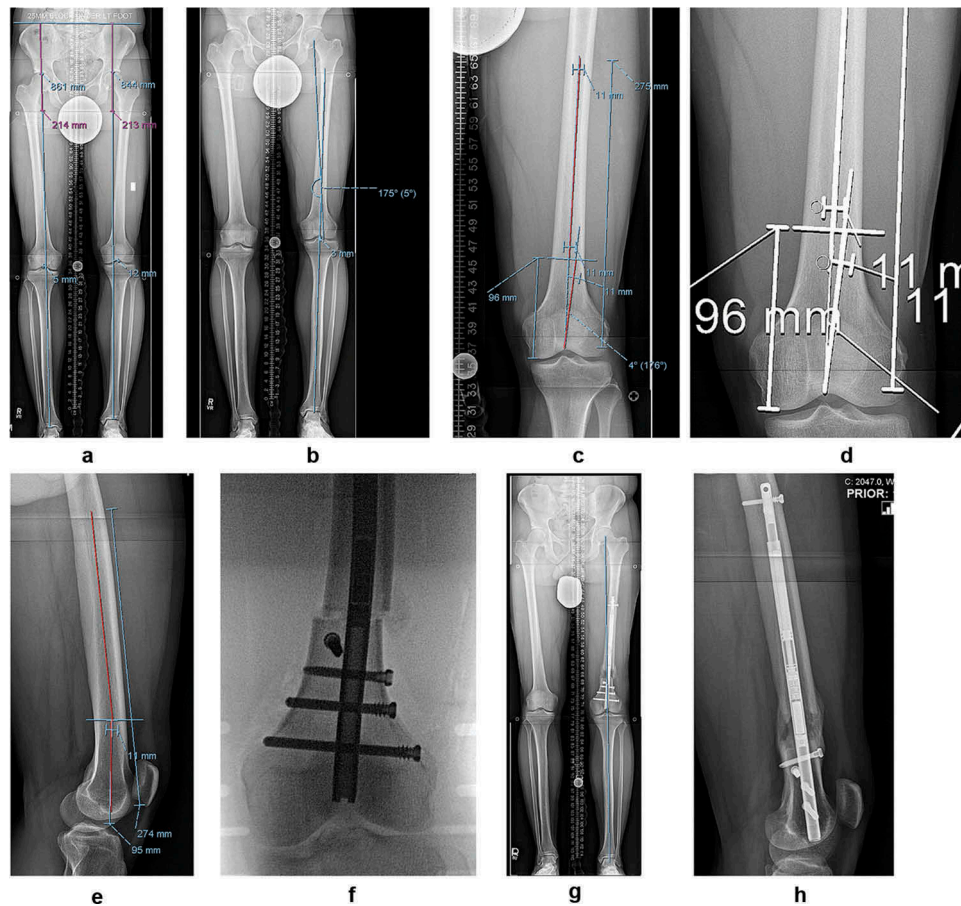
(a) This standing radiograph demonstrates a patient with a 24mm limb length discrepancy. The majority of the shortening stems from the left femur (17mm). There is also a 12mm medial mechanical axis deviation with visibly more varus of the left versus the right leg. Indications for lengthening surgery included non-compliance with a shoe lift, asymmetric coronal alignment, and a safe method for limb length equalization. (b) The tibial mechanical axis (MA) line (distal femur MA line) was placed 2.5mm medial to the knee center to undercorrect the varus. The proximal femur MA line was created normally. The intersection was the osteotomy site. This yielded a 5 deg correction of varus. Placing the distal MA through the center of the knee would have produced 6 deg varus correction. The under-correction of varus allows for the MA to slide laterally 2.5mm during lengthening. (The actual correction planned was reduced to 4 degrees to better match the other side.) (c) The translation of the MA planning to the actual method for nail insertion is demonstrated. The proximal portion of the nail is restricted to sitting straight in the femoral diaphysis (proximal red line). The distal portion needs to start in the center of the femoral notch and then extend along the desired angular correction toward the osteotomy site (distal red line). The osteotomy site needs to be moved distally in order to provide a 4 deg correction. The 11mm lines represent the width of the nail which helps to visualize its path. (d) The circles represent potential sites for blocking screws to assist in an accurate deformity correction. (e) The lateral radiograph of the entire femur is recommended to measure the maximum length of the nail to avoid the proximal femoral bow. In this case, there is minimal bowing in the femoral diaphysis and a 275mm nail will end short of the proximal bow. (f) This intra operative fluoro shot demonstrates the anterior blocking screw placed according to the pre operative planning. A posterior blocking screw has also been inserted. The remainings are seen spilling out of the lateral aspect of the osteotomy site. (g) After 24mm of length the mechanical axis is measured. (h) A final lateral radiograph shows the posterior blocking screw prevented lengthening induced flexion.
